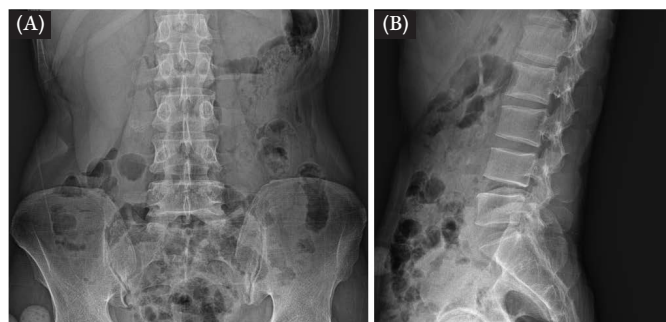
X-ray imaging (November 18th, 2021). (A) Axial X-ray of lumbar spine. (B) Sagittal X-ray of lumbar spine.
